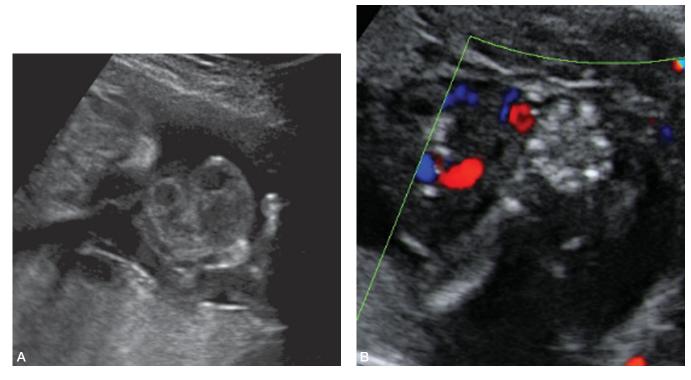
A. Sonographic image of amniotic bands involving the umbilical cord and the right upper extremity. B. Color doppler of the same patient.
